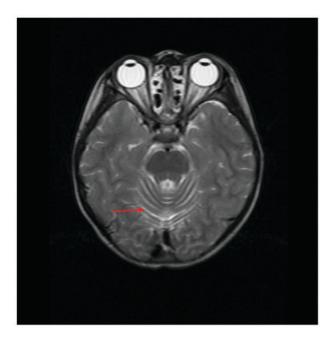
T2-weighted magnetic resonance imaging of the proband. Arrow indicates enlarged cerebellar sulci.
